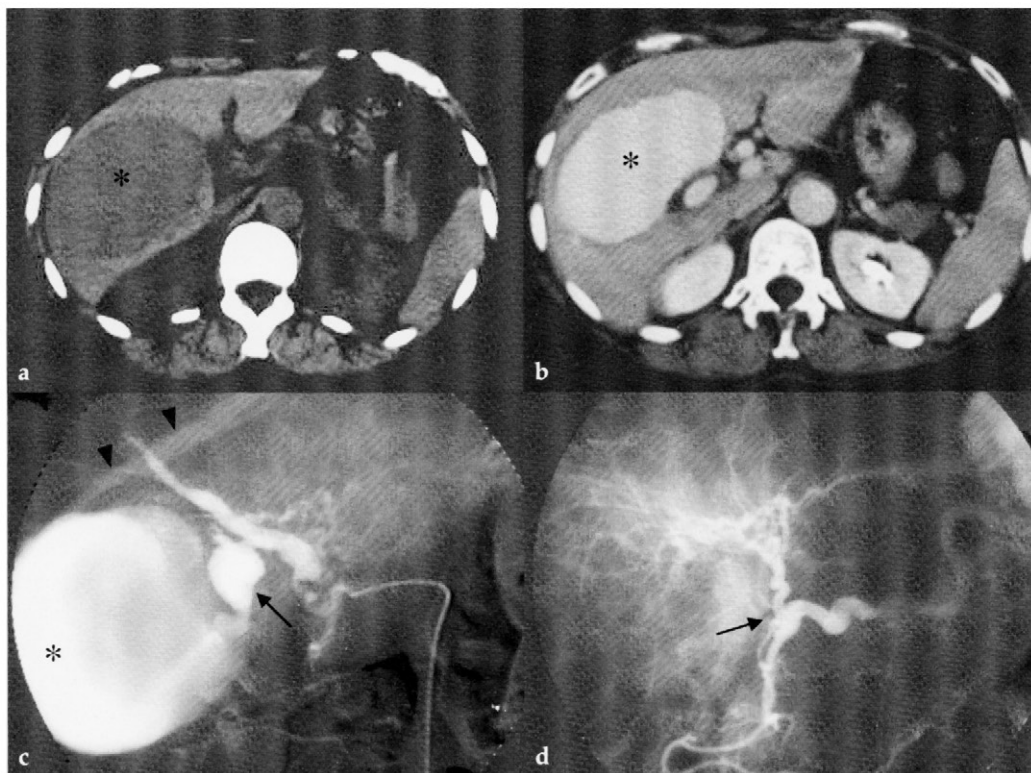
Ruptured aneurysm of the right hepatic artery. CT scans in the pre-contrastographic phases show the presence of a huge intrahepatic hematoma (asterisk)
